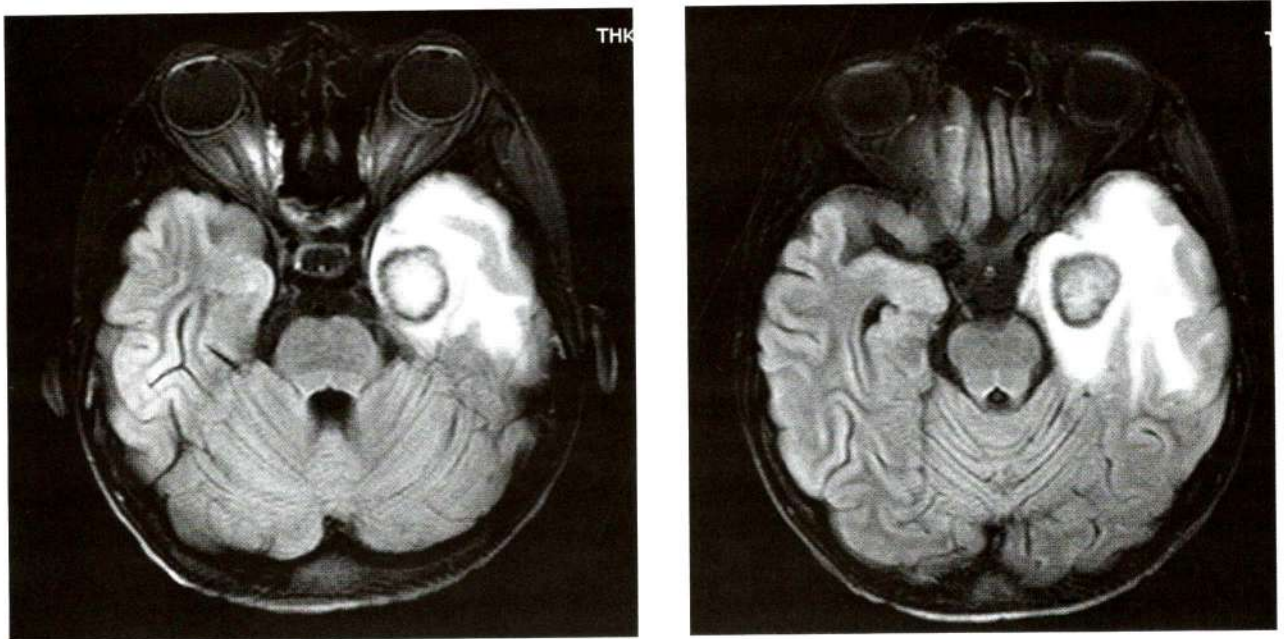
Axial FLAIR showed better demonstration of the signal intensity change as described in Figure 2
